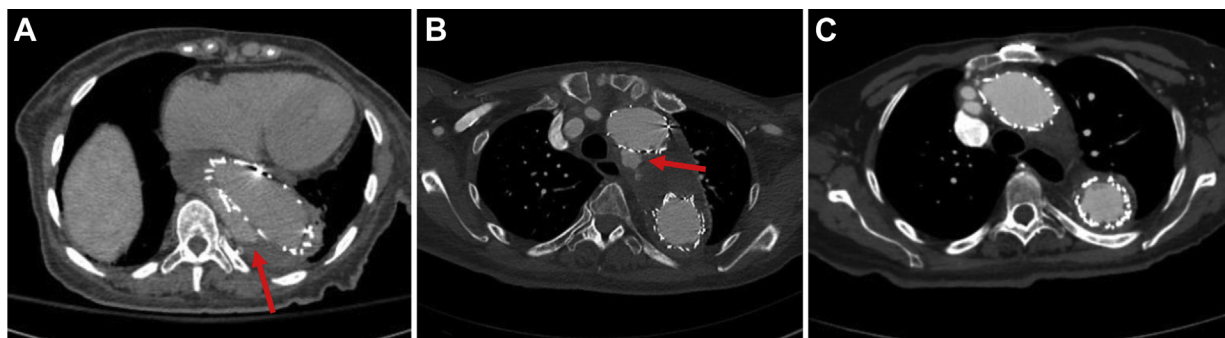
A, Computed tomography (CT) angiogram from August 2019 demonstrating a large type III endoleak (arrow) in the setting of worsening disseminated intravascular coagulation (DIC), which resolved with relining the stent grafts with Navion endografts (Medtronic, Dublin, Ireland). B, A new, more proximal, type III endoleak (arrow) had developed 9 months later with expansion of the aneurysm sac. It was treated with a Relay stent graft (Terumo Aortic, Inchinnan, UK). C, The most recent CT angiogram from February 2021 showing resolution of the endoleak.
